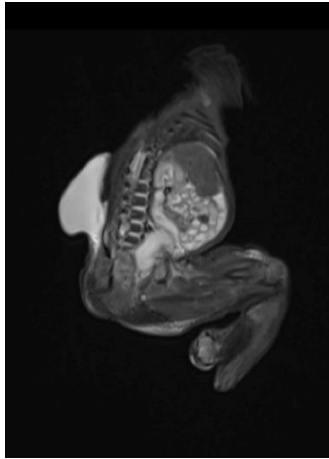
MRI sagittal section showing a well-defined cystic lesion arising from the sacrococcygeal region, hypointense on T1 and hyperintense on T2 — initially interpreted as meningocele.
